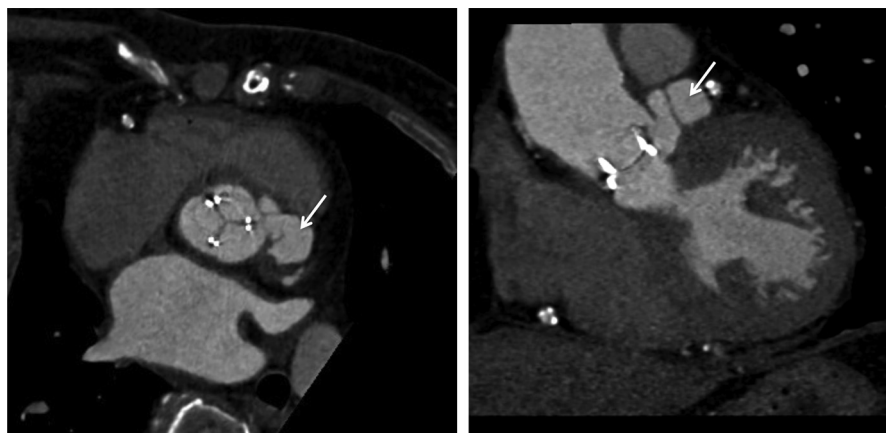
Cardiac computed tomography scan of patient with infective endocarditis on an aortic bioprosthetic valve. The imaging shows a pseudoaneurysm with a prosthetic dehiscence (white arrows) at the level of the anterior part of the annulus.
